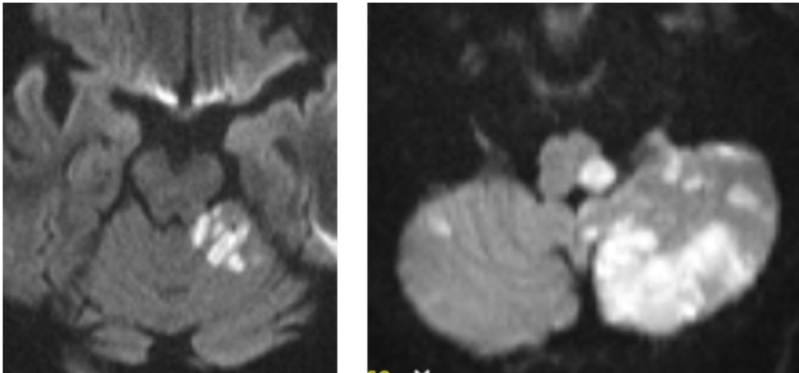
MRI-DWI showing hyperintense areas corresponding to (A) cerebellar infarction, and (B) ischemic lesions involving the left cerebellum and left dorsal brainstem.
